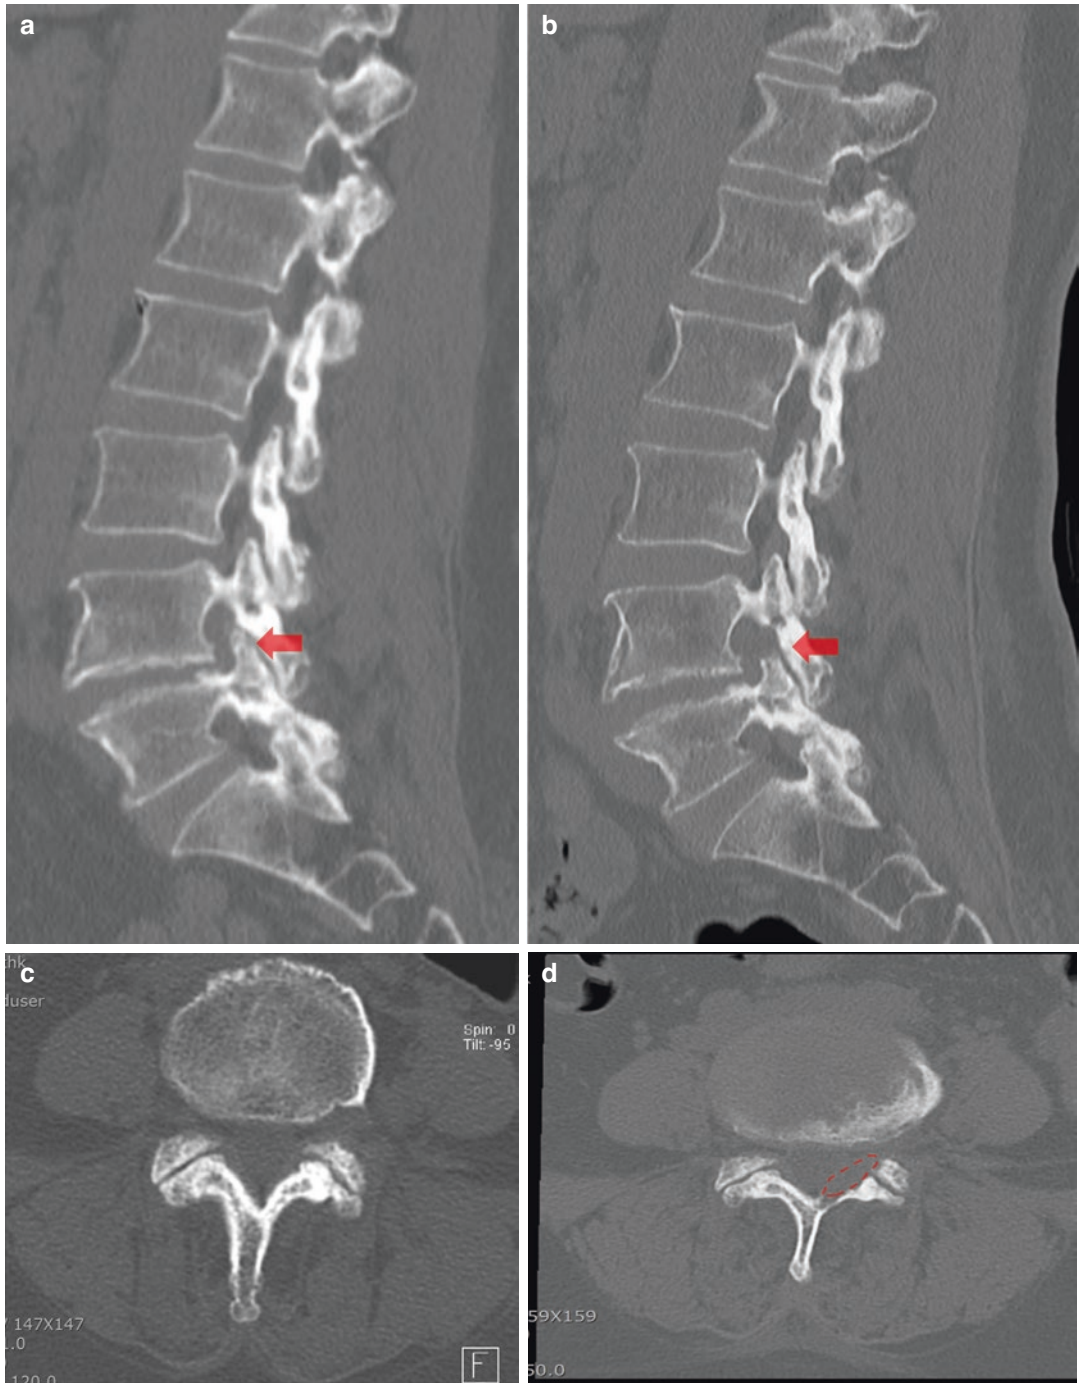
The CT images from a 64-year-old woman underwent O-arm navigation-guided ICELF at the left L4–5 level. Comparing the preoperative images (a, c), postoperative CT images (b, d) showed a widened left L4–5 foramen and subarticular zone after the operation
